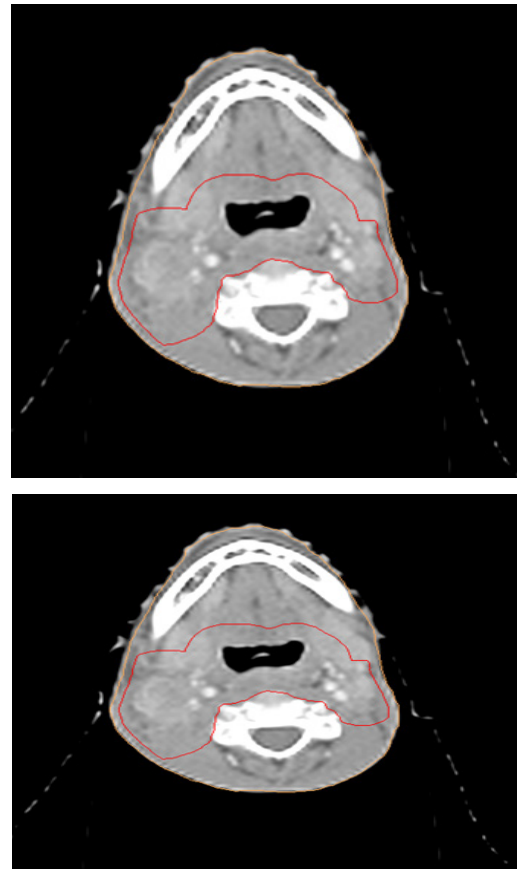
CT Scan showing Gross Hypopharynx disease and Gross involved Nodes.
